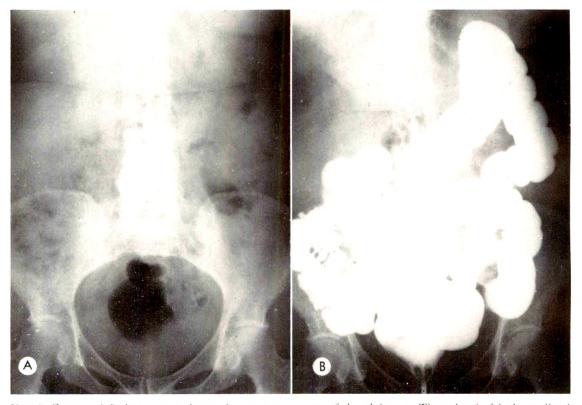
Case IV. (A) Anteroposterior supine roentgenogram of the abdomen. The colon is faintly outlined by retained gas and fecal matter. The hepatic flexure appears depressed. (B) Anteroposterior barium enema roentgenogram. The plain film impression of hepatic flexure depression is confirmed. The colon is intrinsically normal.
